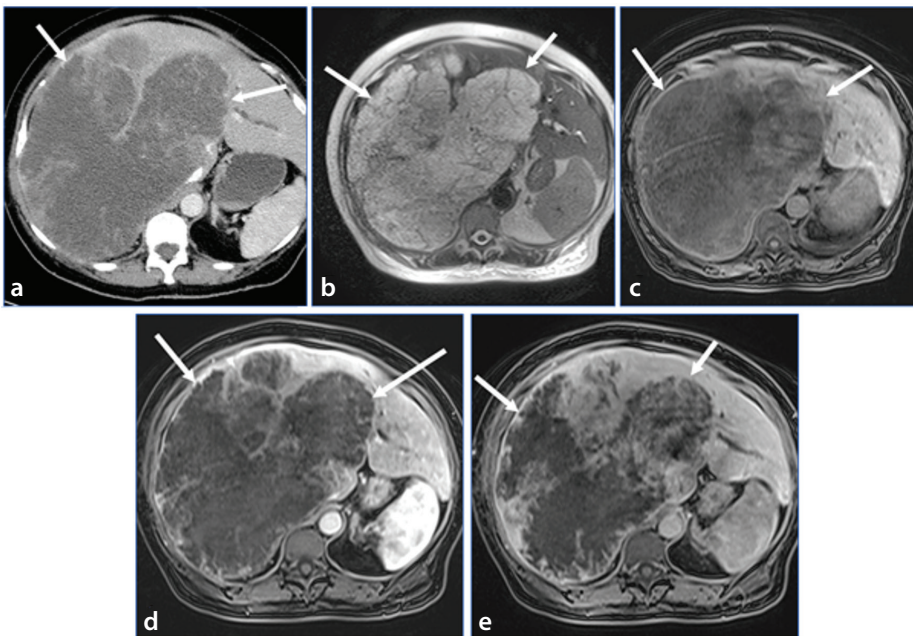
Undifferentiated embryonal sarcoma. Axial contrast-enhanced computed tomography (a) demonstrates a large predominantly cystic mass involving most of the right and part of the left hepatic lobe. Axial T2-weighted imaging (b) shows high signal intensity of the tumor, giving a cystic appearance. Axial dynamic gadolinium-enhanced T1-weighted imaging (c-e) show gradual contrast accumulation, revealing the solid nature of the tumor. This was pathologically proven to be embryonal sarcoma with possible cartilaginous differentiation.
